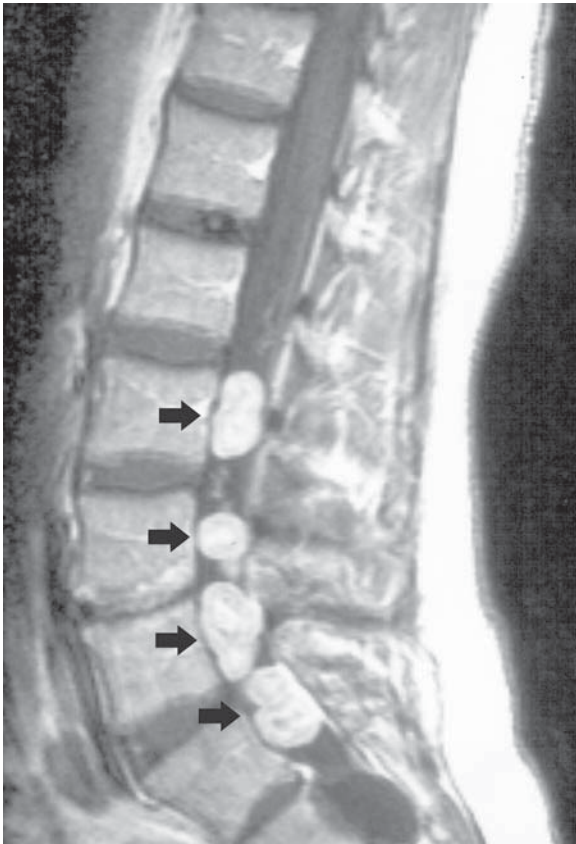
Multiple schwannomas. This patient with neurofibromatosis II has multiple lobulated canal lesions in the lumbar spine. Contrast-enhanced sagittal T1-weighted image demonstrates significant contrast enhancement with mild heterogeneous signal in these lesions.
